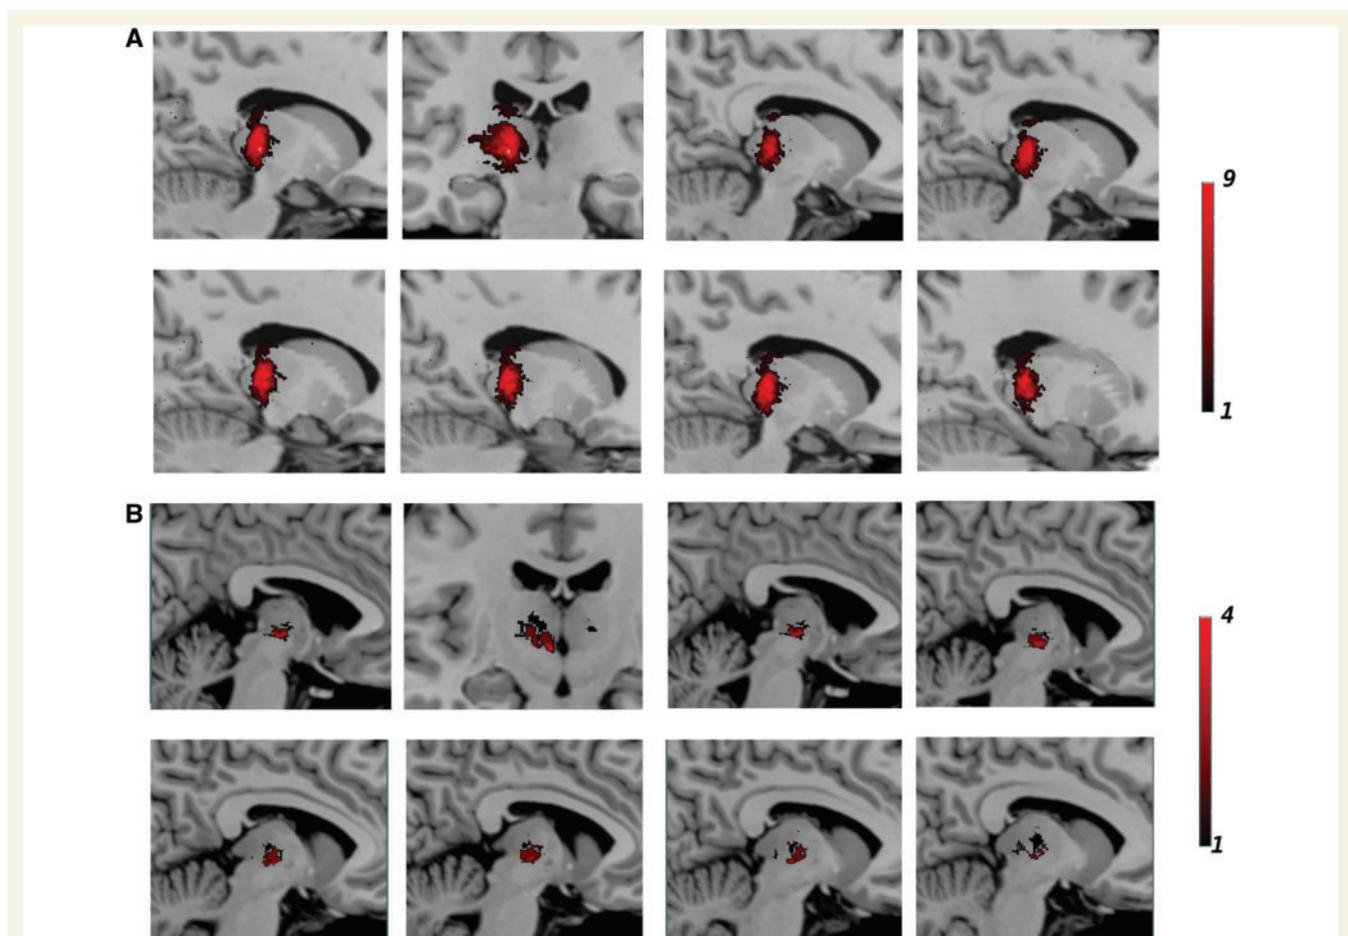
(A) Cumulative (summed) lesion map of the patients with thalamic pain ($n = 10$) in standard stereotaxic space (MNI space). (B) Cumulative lesion map of the control patients ($n = 10$) in standard stereotaxic space (MNI space). The lesion maps are overlaid on a high-resolution T₁ MRI (Colin27 MRI template) in sagittal and coronal planes (Holmes *et al.*, 1998). The colour bars on the right indicate the colour coding of the lesion summation. Please note the different scaling of the images in (A) compared with (B) as indicated by each colour bar.
